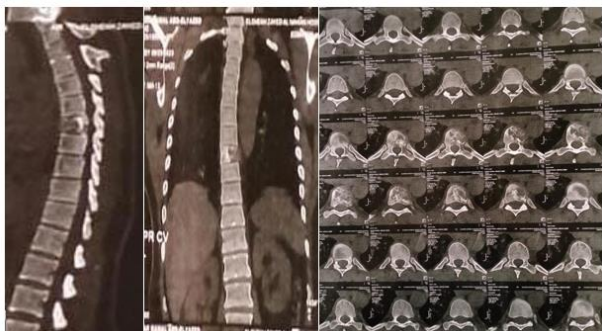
Case 1 CT scan of dorsal spine
